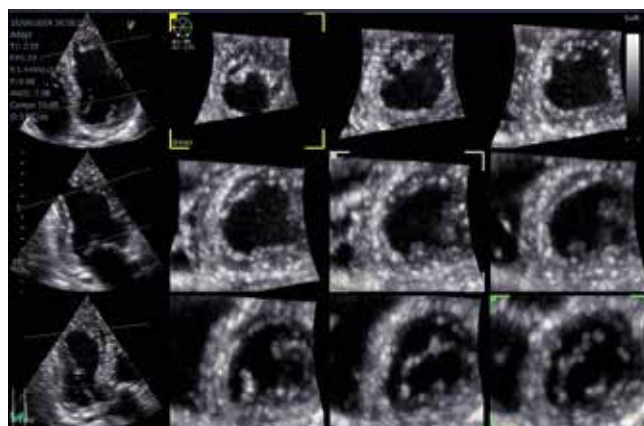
Multislice real-time three-dimensional stress echocardiography for ischemia detection in cancer patients under cancer treatment.
